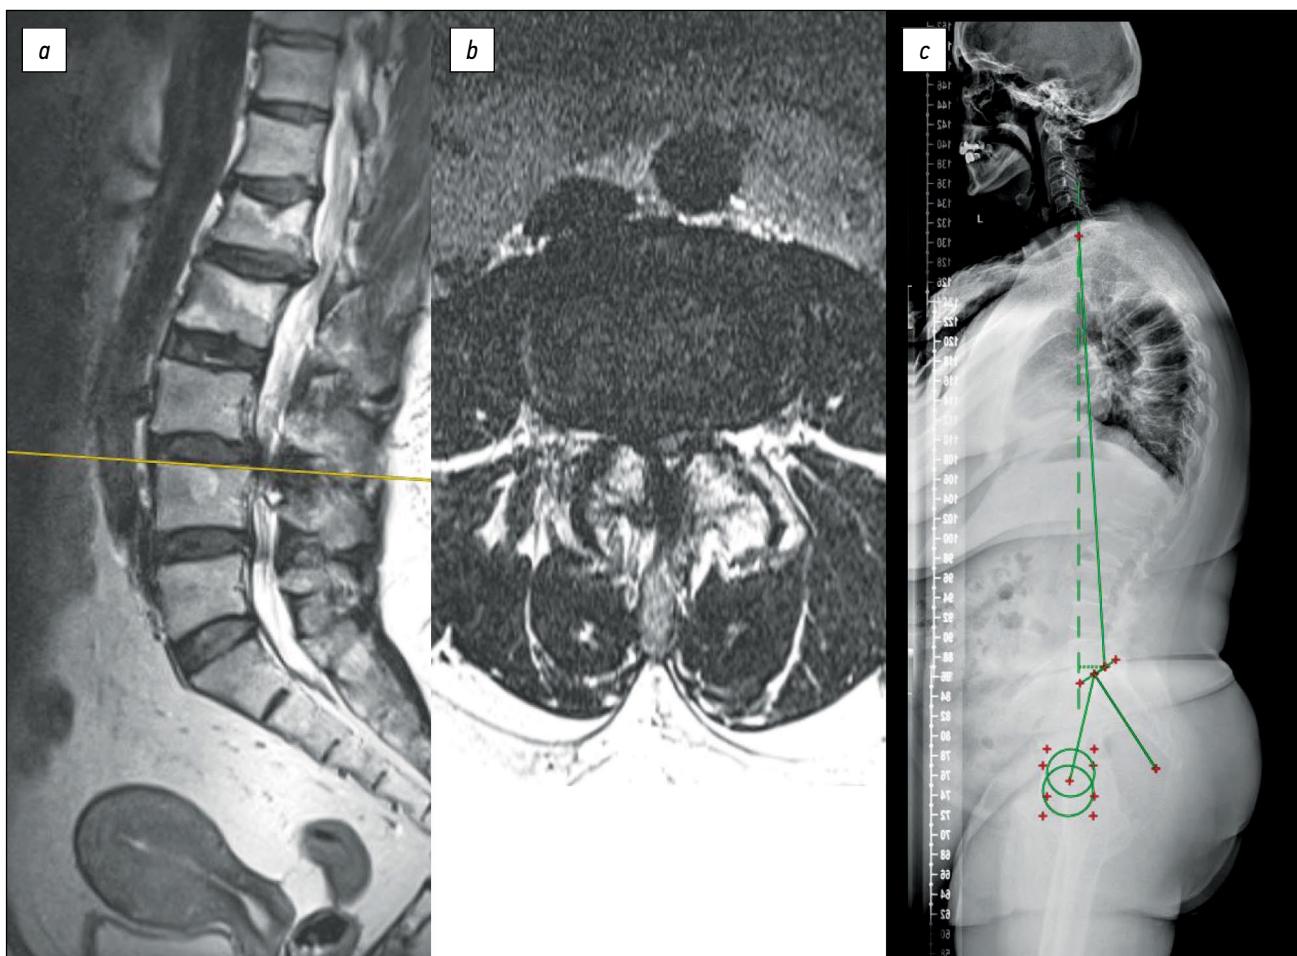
Patient I., 62 years old: VAS in back — 4 points, VAS in legs — 5 points, ODI=64.44%, DN4 before surgery — 7 points; *a, b* — MRI lumbar spine — degenerative stenosis L3-L4, Schizas grade C (Fig. 2, *a, b*); Postural radiography of the spine — Barrey Index =0.71 (Fig. 2, *c*). Surgical treatment — microsurgical “over-the-top” decompression at L3-L4. Despite the achieved recalibration to Schizas grade B, the patient continues to have pain in the lower extremities. ODI — 48.89%, VAS in legs — 4 points, VAS in back — 3 points. Clinical success achieved — ODI regression by 15.5% recalibration of the spinal canal, but the patient is not satisfied with the result of surgical treatment — 3 on the Likert scale (“state without change”). The high value of neuropathic pain remains: DN4=7 points. Surgical treatment defined unsuccessful.
